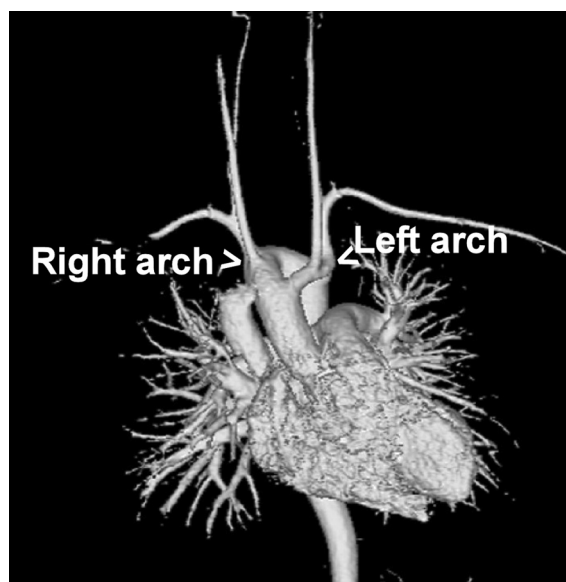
FIGURE e62-6 MRI of a patient with a double aortic arch, a dominant posterior right arch, and a hypoplastic but patent left aortic arch.
